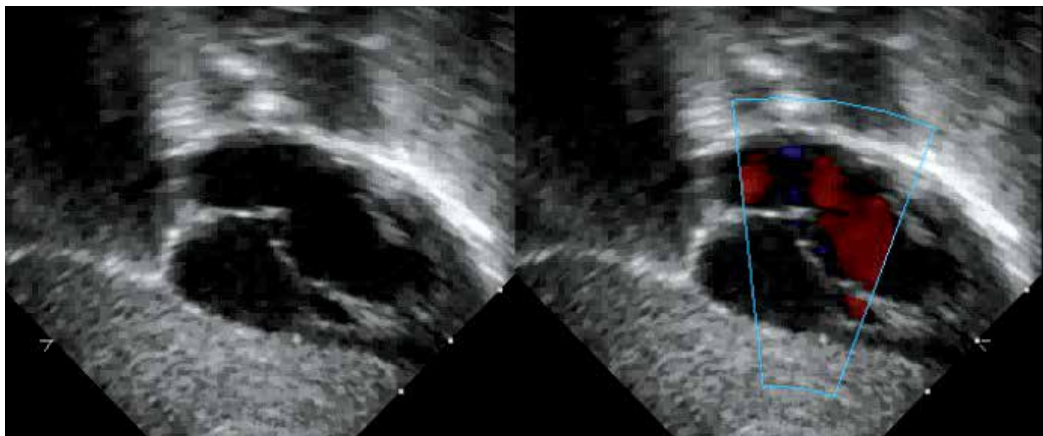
Echocardiographic subcostal four-chamber image demonstrating a patent foramen ovale .
